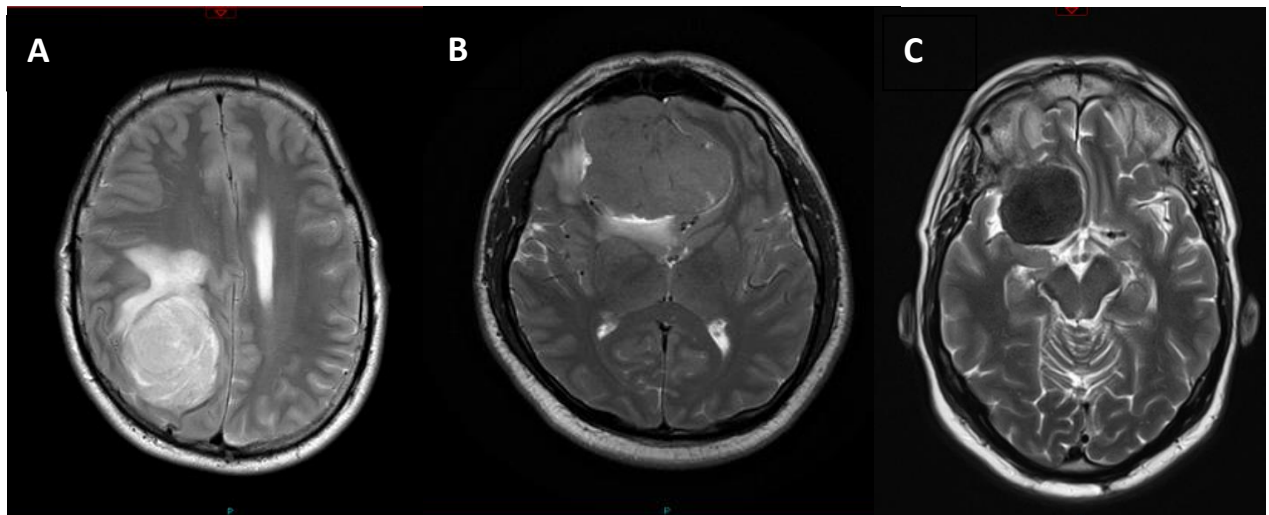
Selection of axial T2- weighted MRI studies demonstrating three meningioma of varying T2 signal intensity compared to cortical grey matter (A) Hyperintense (B) Isointense (C) Hypointense.
